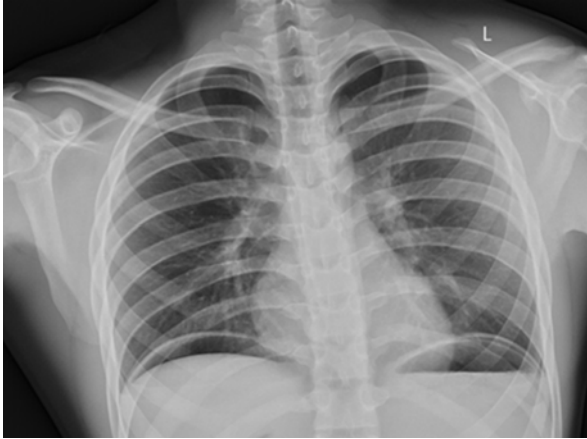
An erect chest X-ray demonstrating free intra peritoneal air
